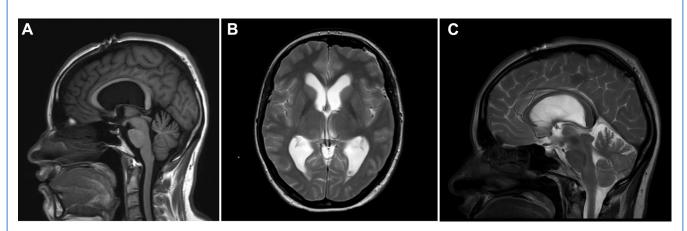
(A-C) T1-weighted/T2-weighted magnetic resonance imaging showing postsurgical endoscopic resection of the colloid cyst with minimal blood layering in the occipital horns of the lateral ventricle and in left
